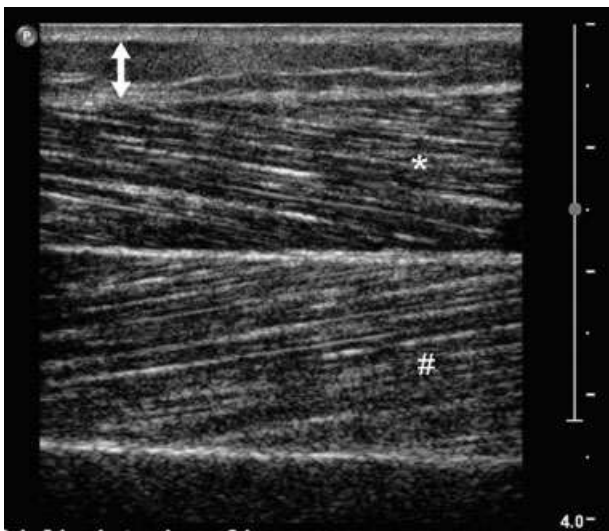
Muscle ultrasound of the proximal part of a normal anterior tibial muscle in longitudinal plane. Note the pennation angle clearly visible in both the superficial part (*) and deeper part (#) of the anterior tibial muscle, separated by the central fascia. Double arrow indicates subcutaneous tissue.
